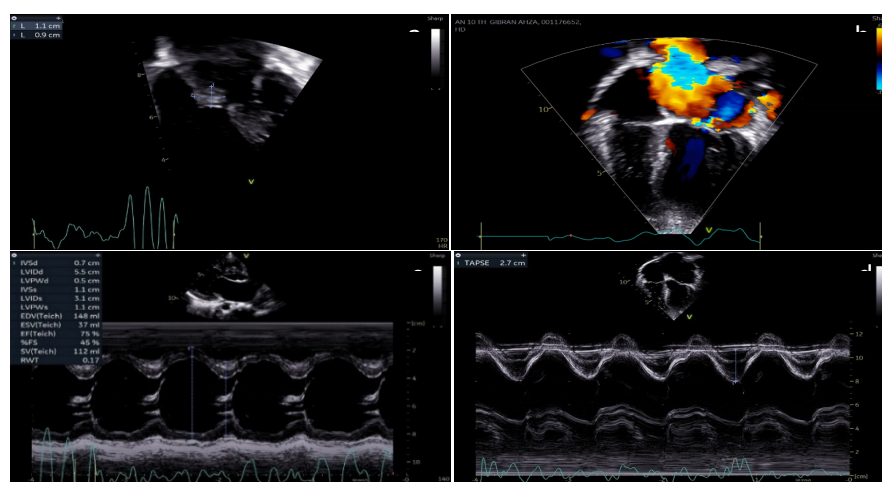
Echocardiography at M. Djamil General Hospital (a) Apical four-chamber view showing vegetation on anterior mitral leaflet (AML) (b) Apical four-chamber view showing severe mitral regurgitation (c) Parasternal long axis M-mode demonstrating ejection fraction 75% (Teichholz method) (d) Apical four-chamber M-mode showing tricuspid annular plane systolic excursion (TAPSE) 2.7 cm
